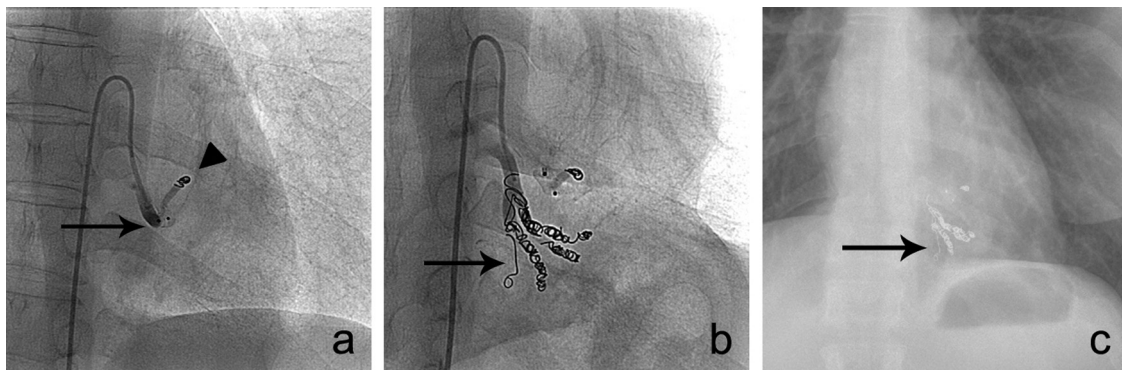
Postembolization control confirms total occlusion of upper aberrant artery (a) with Amplatzer Vascular Plug (arrow) and coil (arrowhead). Lower artery (b) was successfully embolized with coils (arrows). Control chest radiography 10 days after procedure is normal (c); embolization material is seen in medial aspect of left basal lung (arrow).
